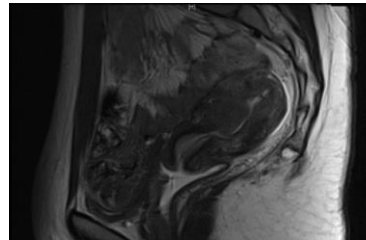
T2 MRI image of persistent mass within the endometrial cavity
